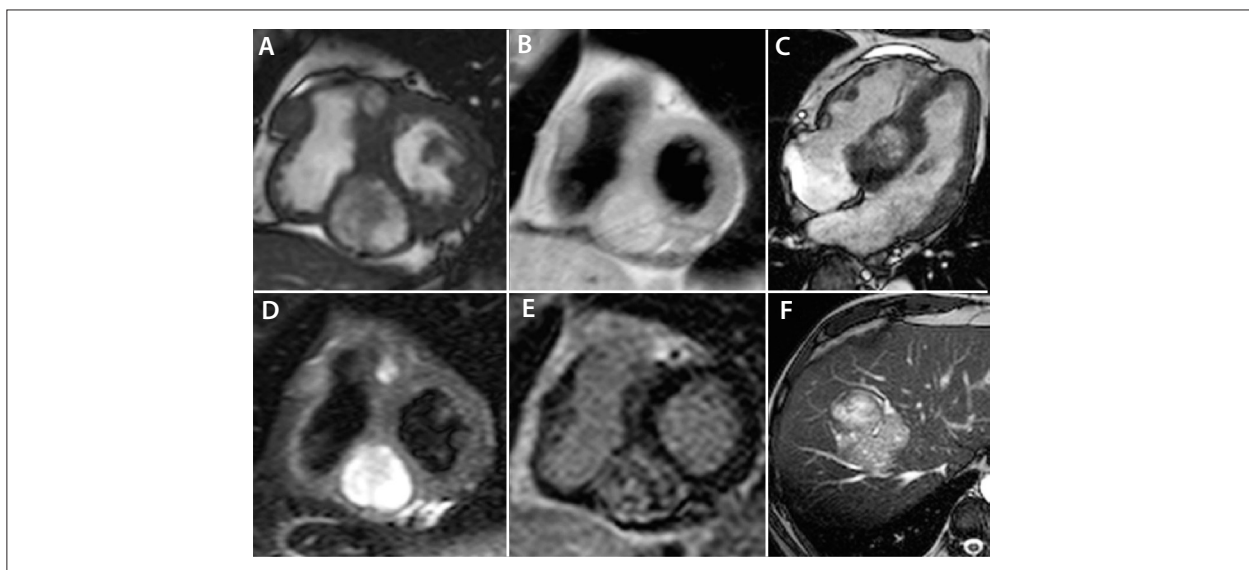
Magnetic resonance imaging. Multiple cardiac metastatic lesions (A-E). A and C: Cardiac short axis and four-chamber steady state images. B and D: Cardiac short-axis double and triple inversion-recovery images. E: Cardiac short-axis late enhancement image. F: Isolated hepatic metastatic lesion, abdominal axial steady state image.
